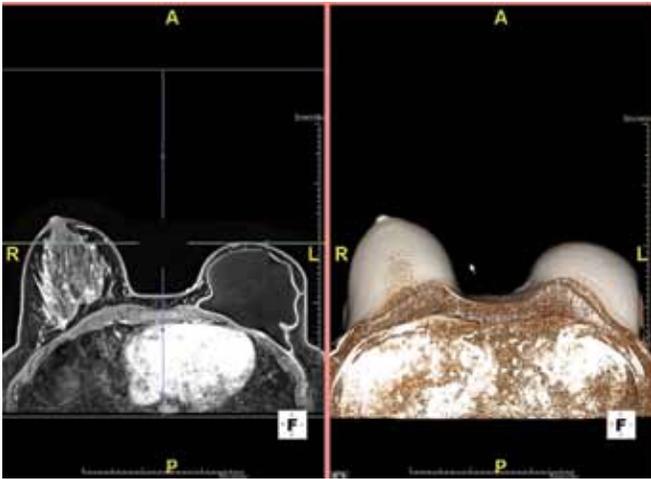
Reconstructed left breast with implant failure and disease in right breast; CT from Siemens.
